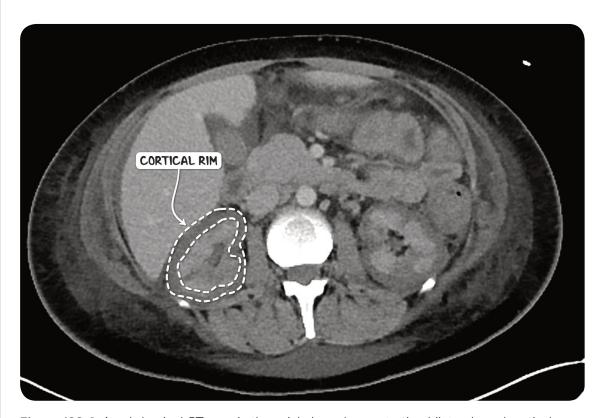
An abdominal CT scan in the axial plane demonstrating bilateral renal cortical necrosis. The low-signal renal cortex surrounding the relatively high-signal renal medulla is known as cortical rim sign.
